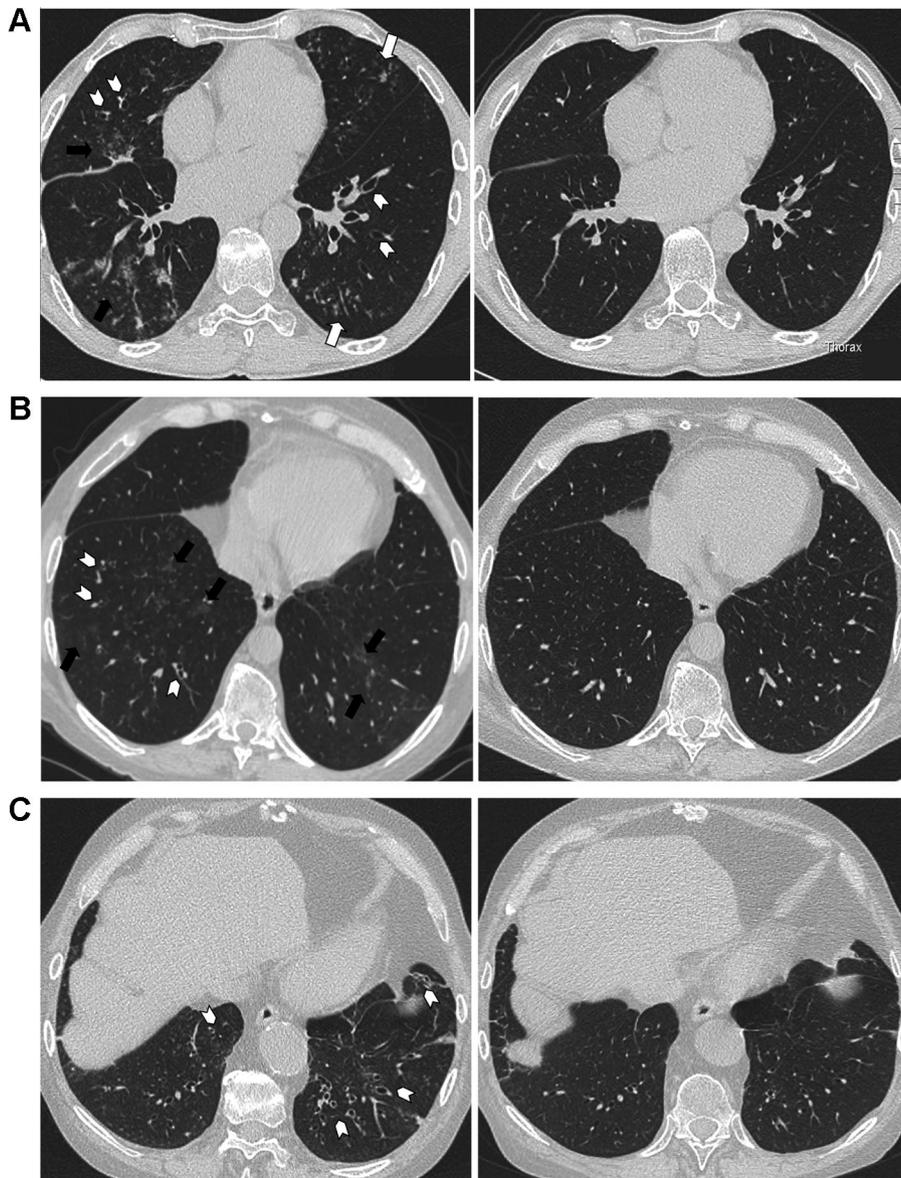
Radiologic features on chest computed tomography in three patients during and 3 months after diagnosis of posttransplant lymphocytic airway inflammation demonstrating regression of centrilobular nodules (tree-in-bud) (A; white full arrow), ground glass opacities (A and B; black full arrow) and bronchial wall thickening (A, B and C; white arrowheads).
